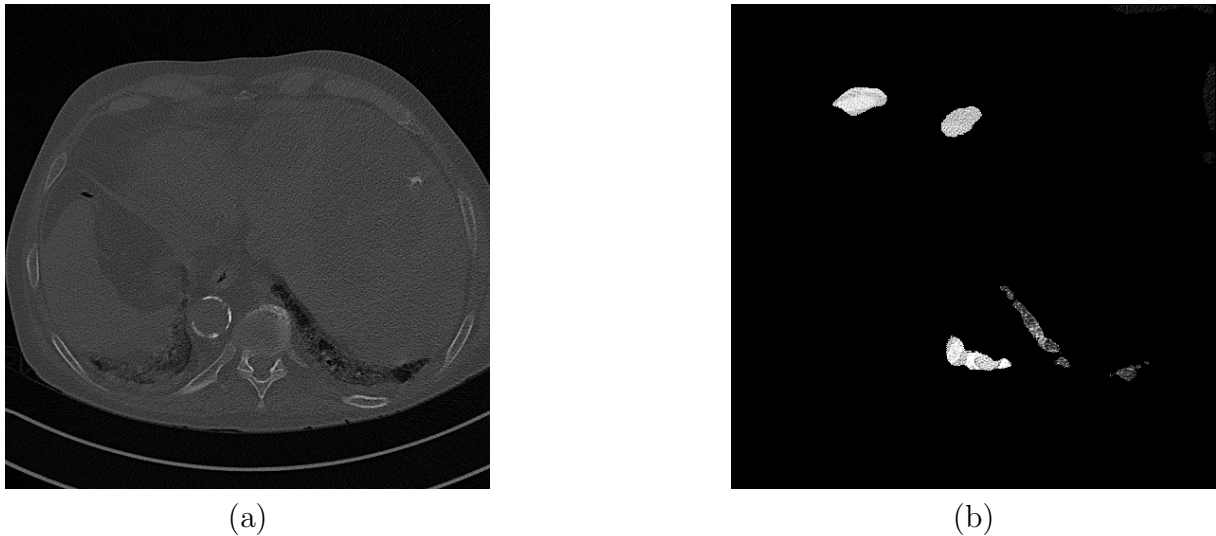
Example of CT Slice used only on Non-segmented classification framework. (a) Non segmented image. (b) Segmented image where lung parenchyma isn't preserved.
